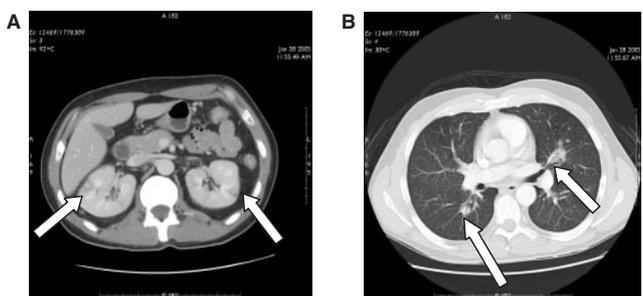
Repeat CT with marked reduction in the renal mass and new renal and pulmonary lesions (marked with arrows).
